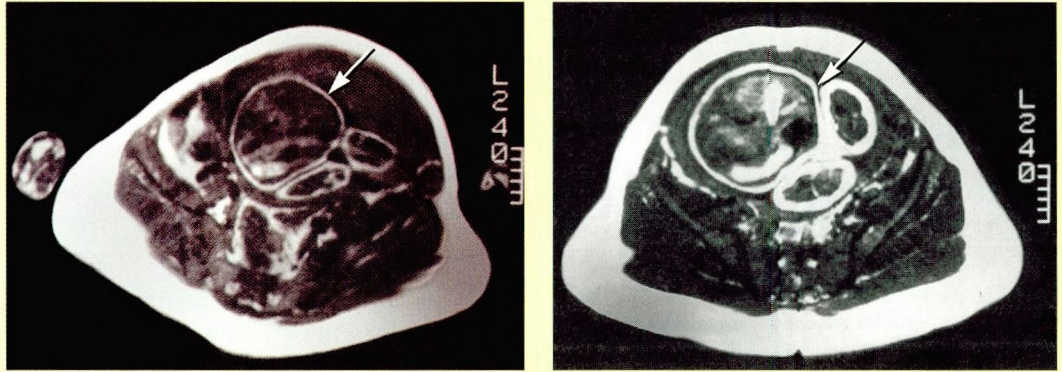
Left, a magnetic resonance image of a woman with well-controlled gestational diabetes, taken at the maternal umbilicus at 38 weeks of gestation. The fetus (arrow) weighed 3,900 g at birth and was normal for percent body fat. Right, Another woman, with poorly controlled gestational diabetes at 38 weeks of gestation. This fetus weighed 3,940 g at birth, had 50% of its neonatal weight composed of fat, and had all of the stigmata of the infant of a diabetic mother.
